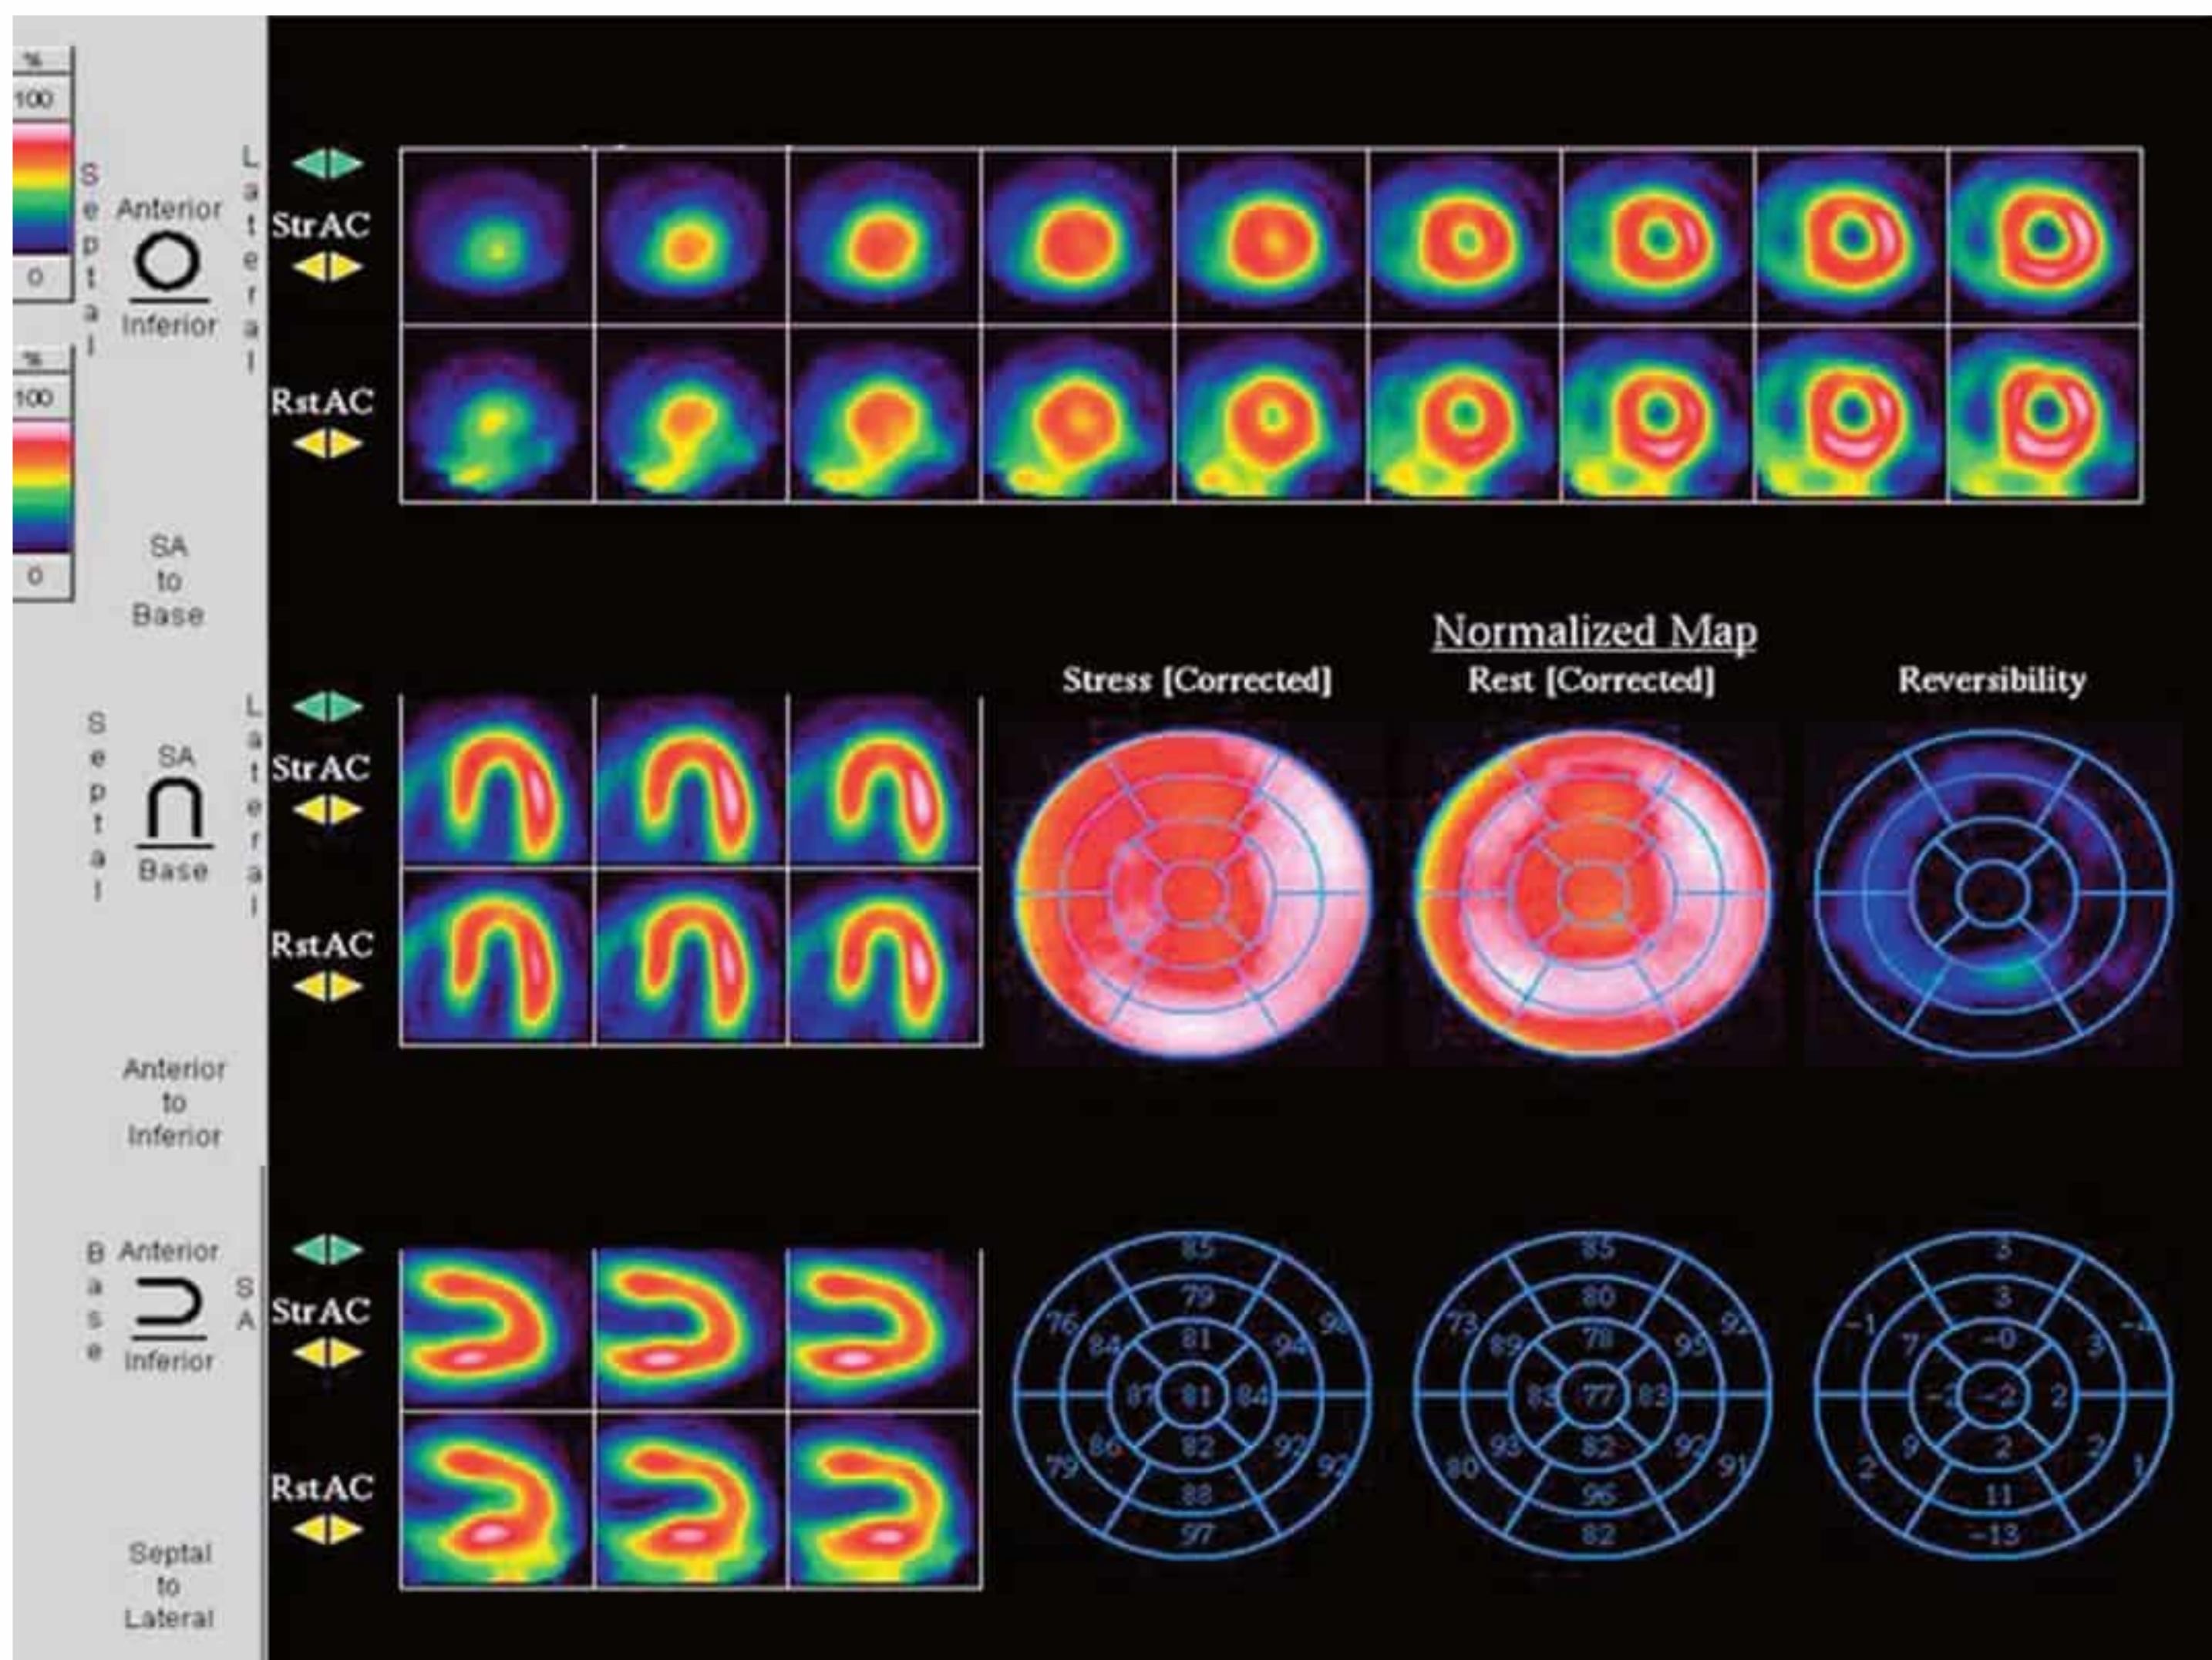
Normal findings in myocardial scintigraphy.
